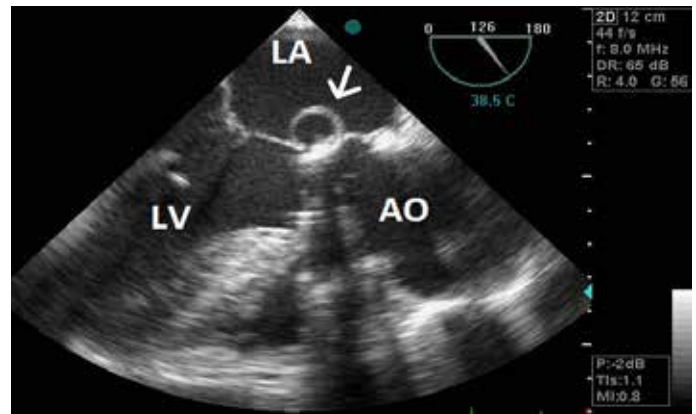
Transesophageal echocardiography views showing a pseudoaneurysm in the mitral-aortic intervalvular fibrosa (arrow)
